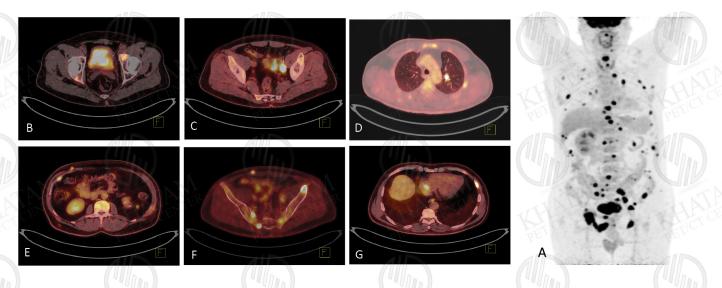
Known case of high grade papillary urothelial carcinoma, status post TURB, referred for staging [A; MIP]. FDG-avid left lateral urinary bladder wall thickening resembles the primary malignancy[B], FDG-avid metastatic left external iliac lymph nodes [C], few metastatic pulmonary nodules [D], sub-cutaneous and muscular lesions [E], skeletal metastases [F], and a pericardial lesion [G].
